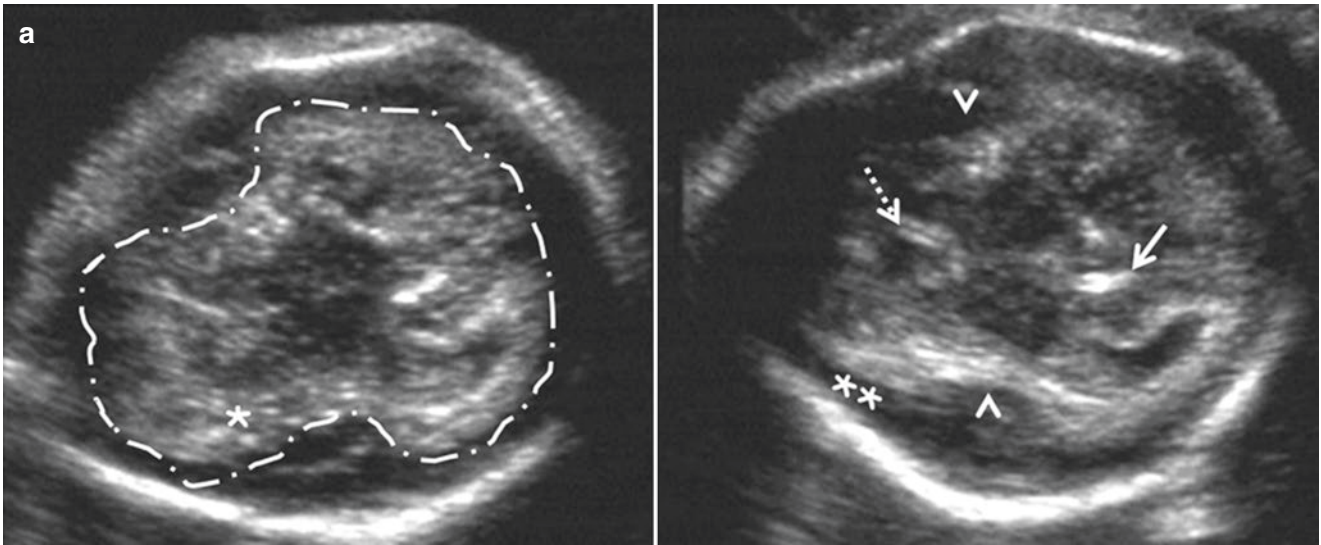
(a) 26 weeks (TAS and MRI) *classical lissencephaly with cerebellar hypoplasia* – axial transventricular and transcerebellar sections, right and left hands – prominent subarachnoid space (\*), shallow obtuse angle-shaped lateral fissure (arrowhead), parieto-occipital sulcus is barely seen (dotted arrow), cerebellar hypoplasia (TCD < fifth centile), bilateral hand joint contractures (solid arrows). Fetal tonic-clonic
